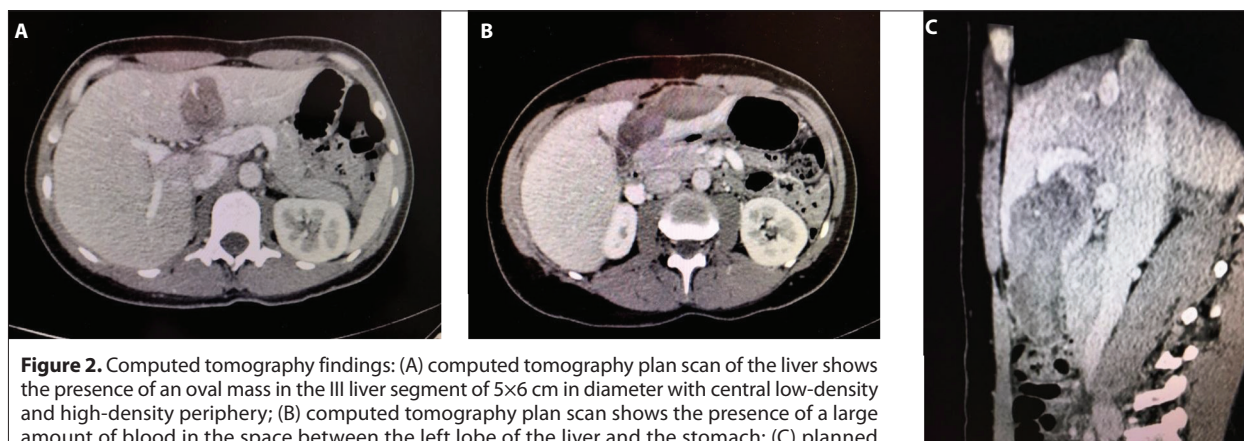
Computed tomography findings: (A) computed tomography plan scan of the liver shows the presence of an oval mass in the III liver segment of 5×6 cm in diameter with central low-density and high-density periphery; (B) computed tomography plan scan shows the presence of a large amount of blood in the space between the left lobe of the liver and the stomach; (C) planned computed tomography longitudinal cross-section of the left lobe of the liver with the presence of blood in the space between the liver and the stomach
